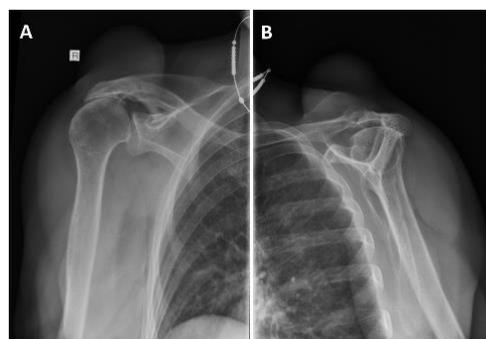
A) Anteroposterior X-ray of the right shoulder revealing a grade IV rotator cuff-tear arthropathy with superior migration of the humeral head, acetabularisation, narrowing and arthritis of the glenohumeral joint space and soft tissue mass over ACJ. B) Scapula Y X-ray of the right shoulder showing larger soft tissue massive over ACJ and superior migration of the humeral head.
